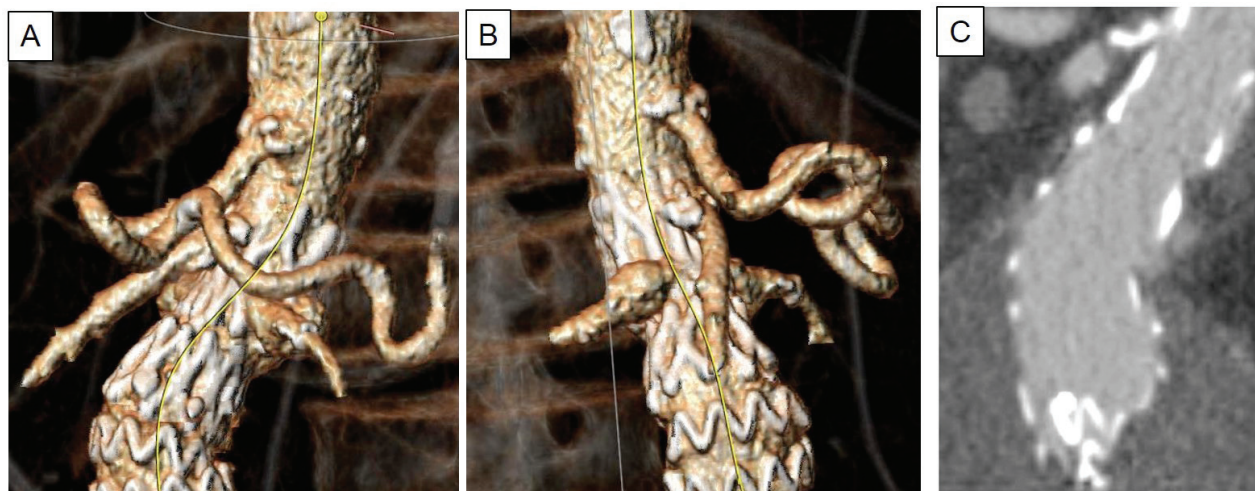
Post-operative CTA confirmed none type Ia EL after intraoperative re-ballooning (case #2). A, B) volume rendering (left and right oblique view, respectively). C) multi-planar reconstruction.
